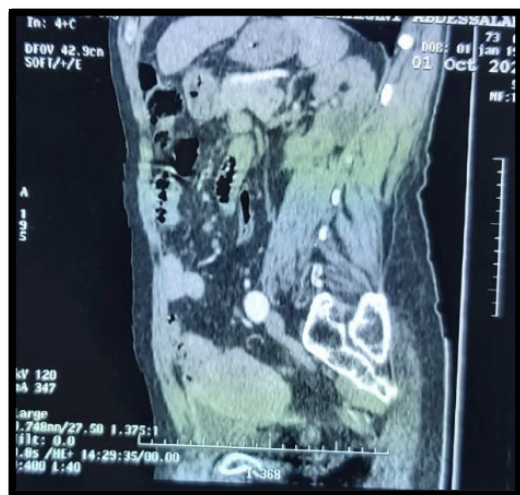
CT scan showing a large pelvic tumor
